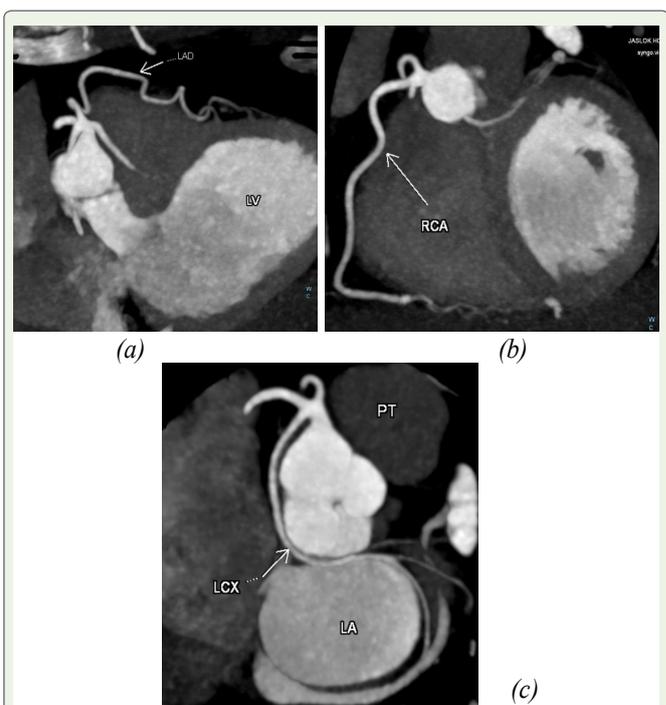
This figure outlines the reformatted oblique CT angiographic images showing the course of the other major coronary vessels, namely (a) LAD (b) RCA (c) Lcx
